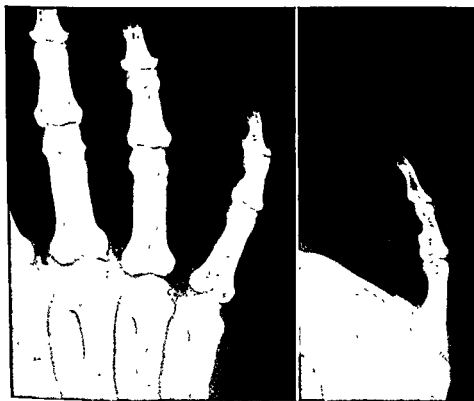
Roentgenographic evidence that a giant-cell tumor has eroded the volar and the radial aspects of the middle phalanx of the little finger.
